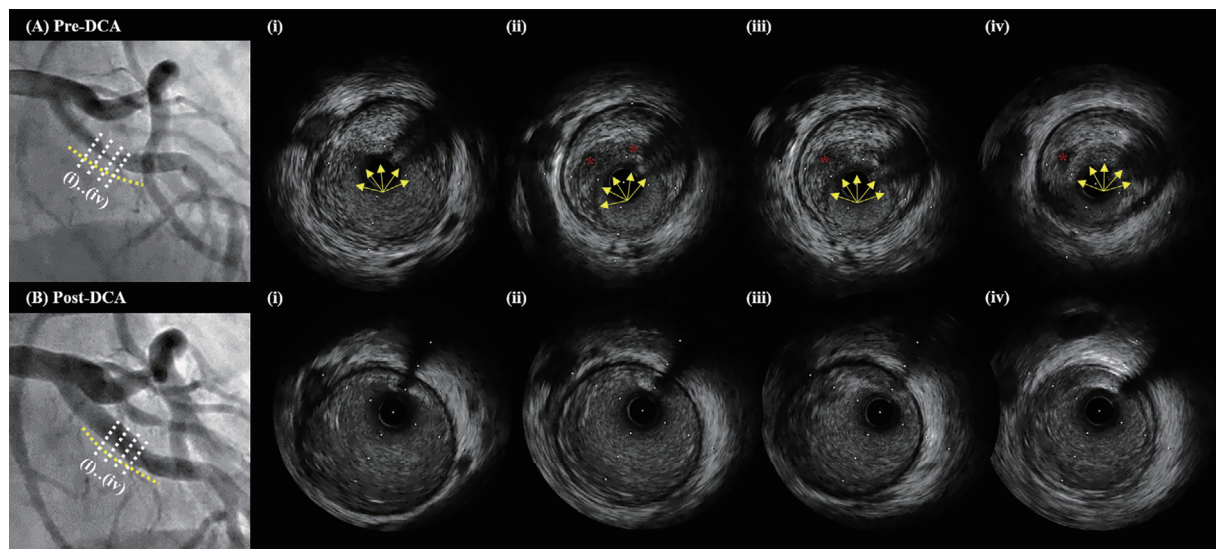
Comparison of the intravascular ultrasound (IVUS) images in the culprit lesion between (A) pre-directional coronary atherectomy (DCA) and (B) post-DCA. The red asterisks indicate intra-plaque hemorrhage. The plaque region resected by DCA was indicated by yellow arrows in the initial IVUS images.
